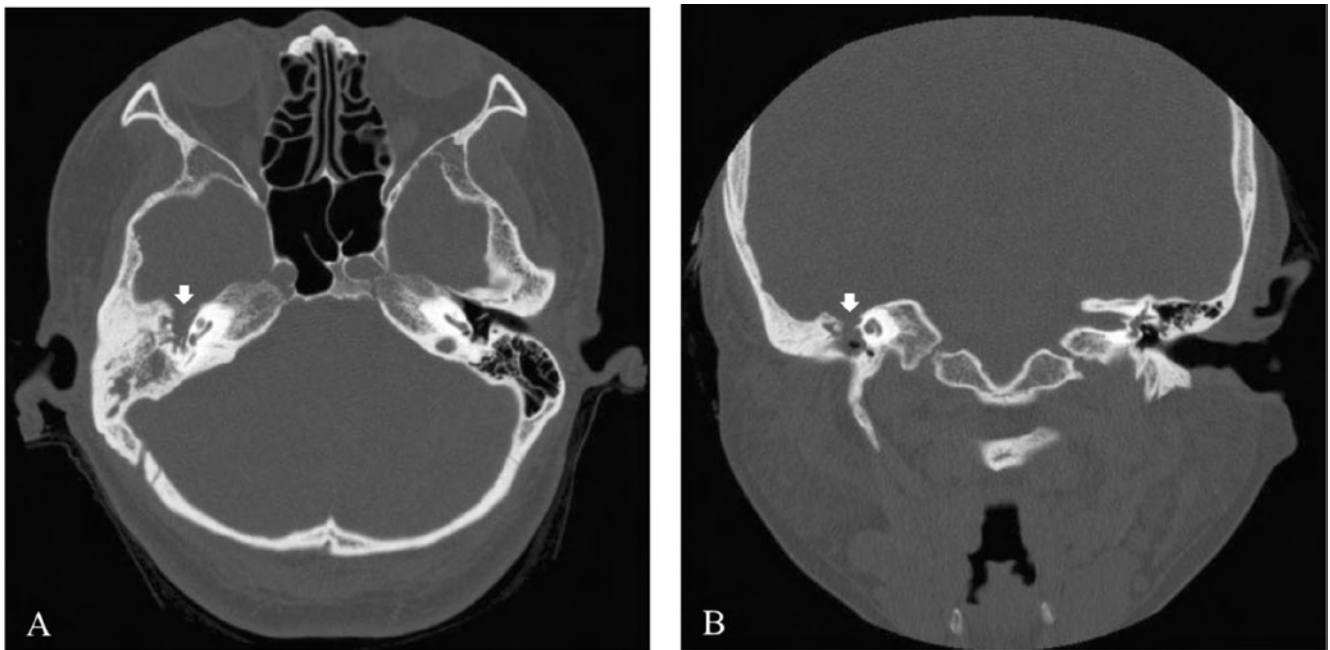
Pre-operative HRCT scan of the temporal bone. The axial image (A) demonstrates a large bony defect of the right anterior wall of the epitympanum (arrow). The coronal image (B) shows a bony defect of the right middle cranial fossa. Also, the tympanic and mastoid cavities are filled with soft-tissue density.
